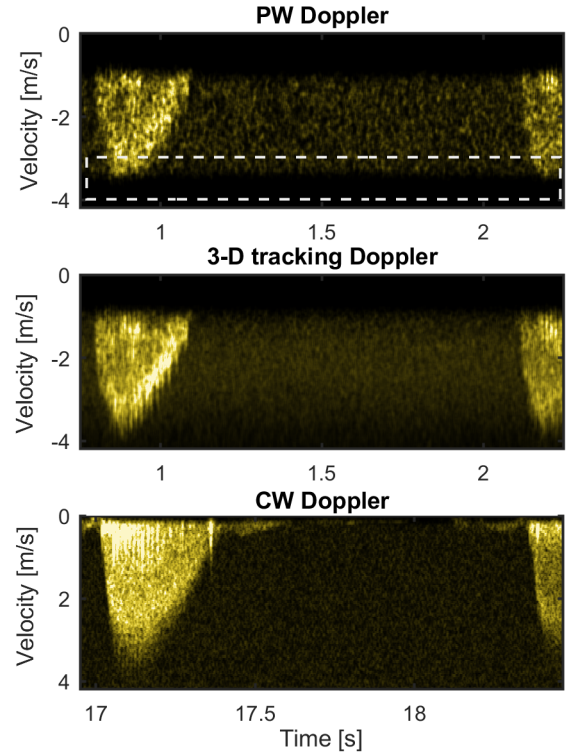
In vivo* example of velocity spectra from subject 7, whose results are summarised in Table III. The estimated beam-to-flow angle was  $28^\circ$ . A CW Doppler spectrum from a more lateral apical view is shown for reference. The white box highlights the region in the PW Doppler spectrum where the signal is attenuated by the clutter filter.
